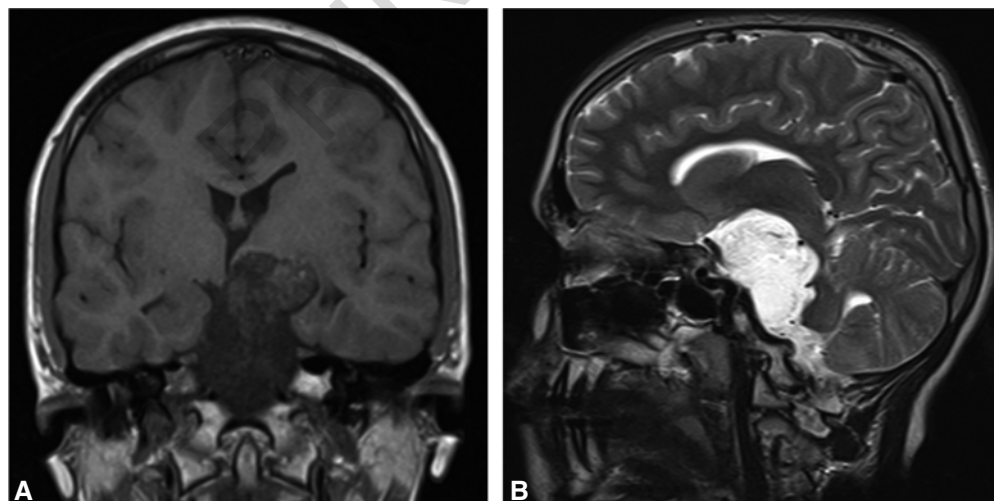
(A) Preoperative T1-weighted coronal MR images; (B) T2-weighted sagittal images showing the epidermoid cystic lesion.
